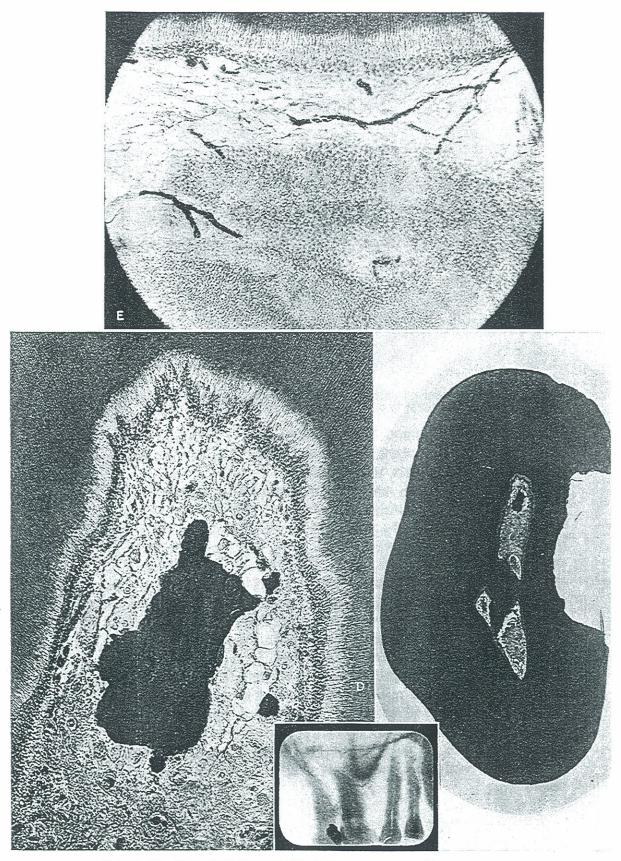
Pulp involvement and metallic filling: B, roentgenographic; A, cross section of cavity and pulp; D, pulp stones; and E, hyperemia and fibrosis.
